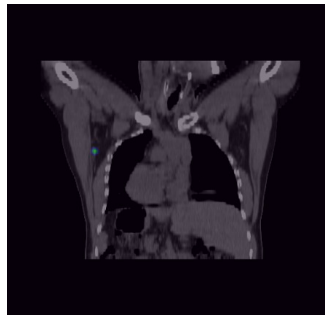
Case No. 2: lymphoscintigraphy with positive anterior axillary sentinel lymph node.
